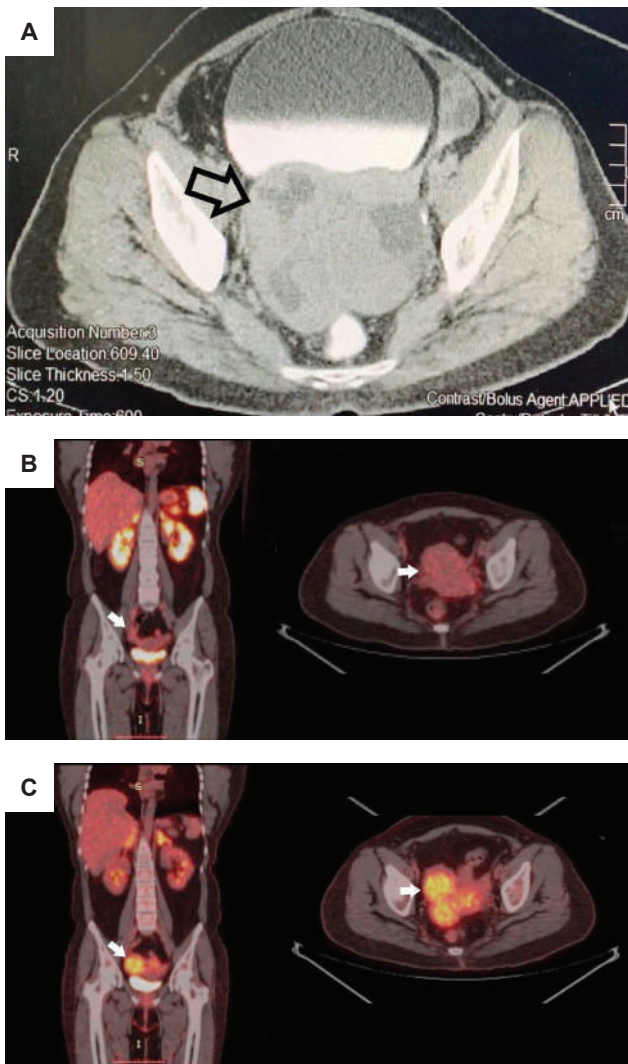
(A) CT image showing heterogenous multilobulated pelvic lesion; (B) Ga-68 DOTANOC PET-CT showing pelvic lesion with no SSTR avid disease. (C) FDG PET-CT showing FDG hypermetabolism of the pelvic lesion.
